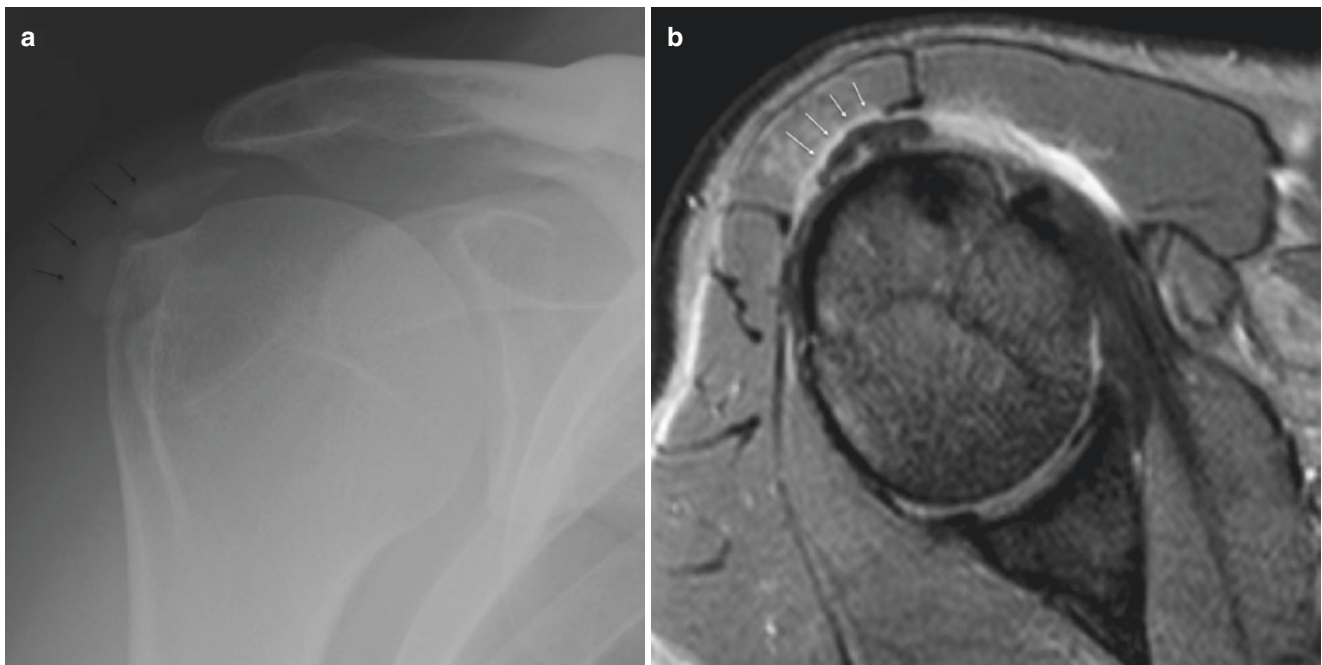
Rotator cuff hydroxyapatite deposition disease. (a) AP radiograph shows periarticular calcifications; (b) axial GET2; (c) coronal PD FSE fat sat WI shows coarse ovoid calcification in the subacromial subdeltoid bursa surrounded by fluid indicating inflammation
